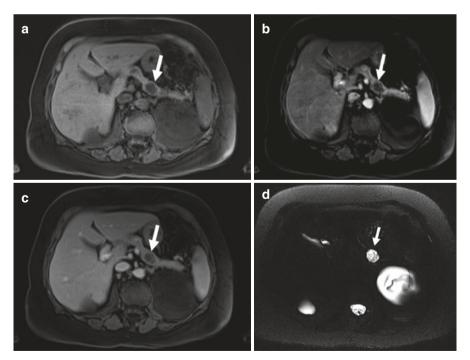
IPMN with malignant degeneration into pancreatic adenocarcinoma. MRI (a, T1WFS; b, T1WFS w/gad arterial phase; c, T1WFS w/gad portal venous phase; d, T2W axial; e, T2W coronal) shows a complex but primarily cystic mass in the head of the pancreas with irregular, nodular-enhancing internal septations (*arrows*)
